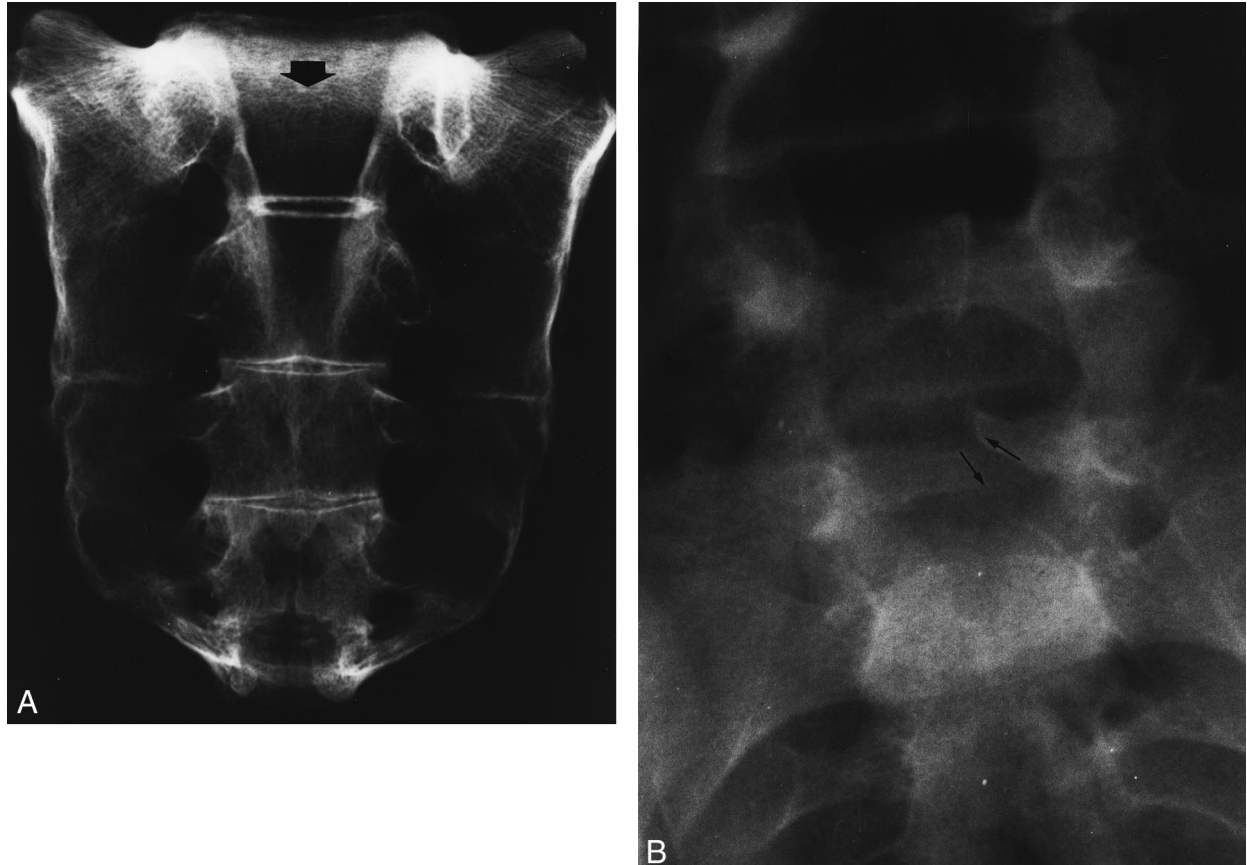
(A) Postmortem radiograph of the sacrum with complete spina bifida in S1–S2. Arrow indicates the superior opening of the defect. (B) Antemortem radiograph of the lumbar and sacral vertebrae. The fifth lumbar spinous process is unfused. Arrows indicate the margin of the defect, i.e. lack of vertebral arch and processes. The identification was ruled out based on the morphologic expression of the condition.
